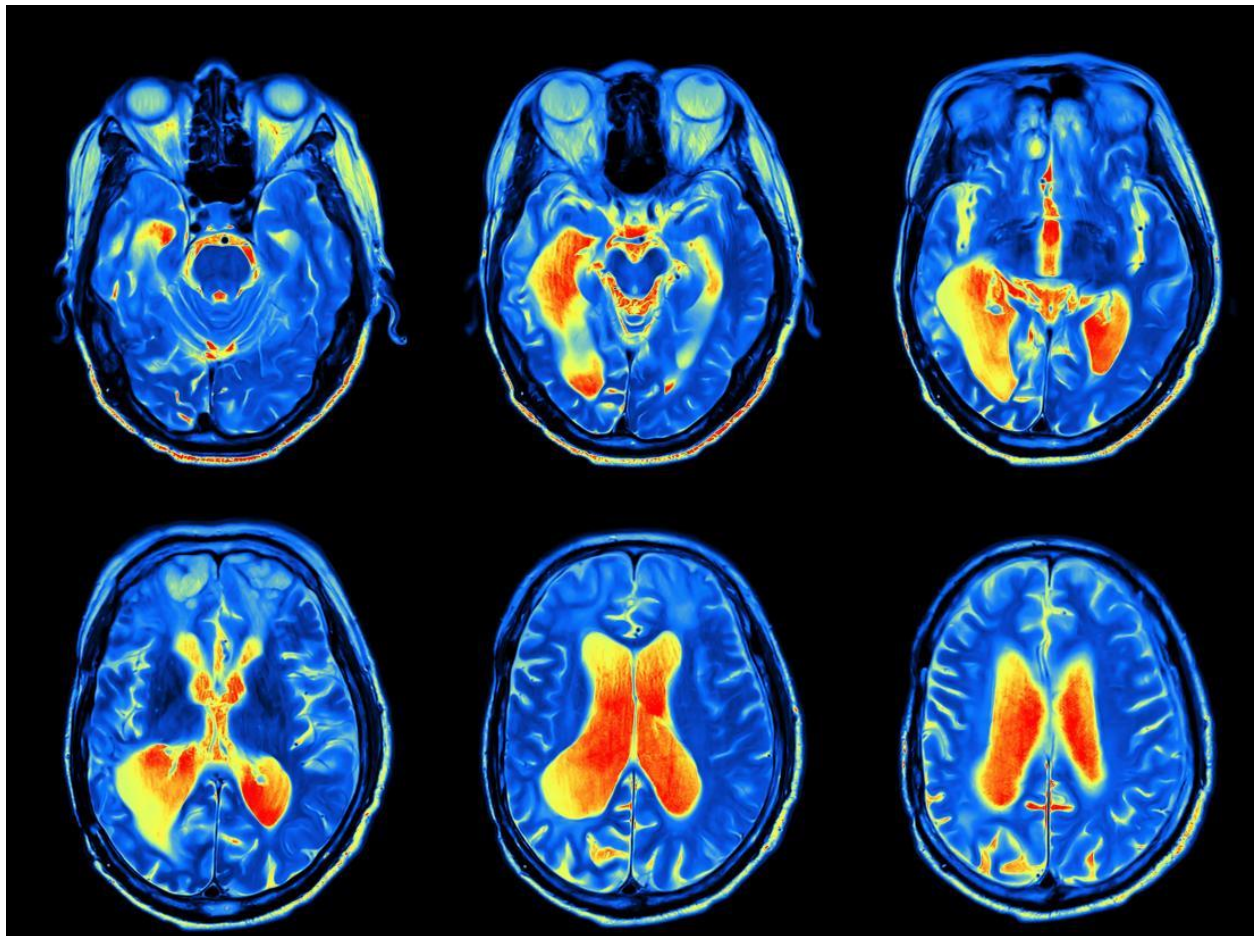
Using MRI how rheumatoid arthritis inflammation changes the brain (Ana Sandoiu, 2018).
